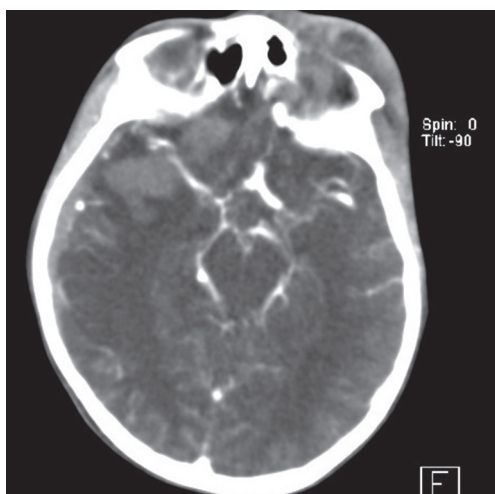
CT angiogram showing abrupt cutoff of the right middle cerebral artery and the intracranial bleed and infarct that caused the mass effect.
